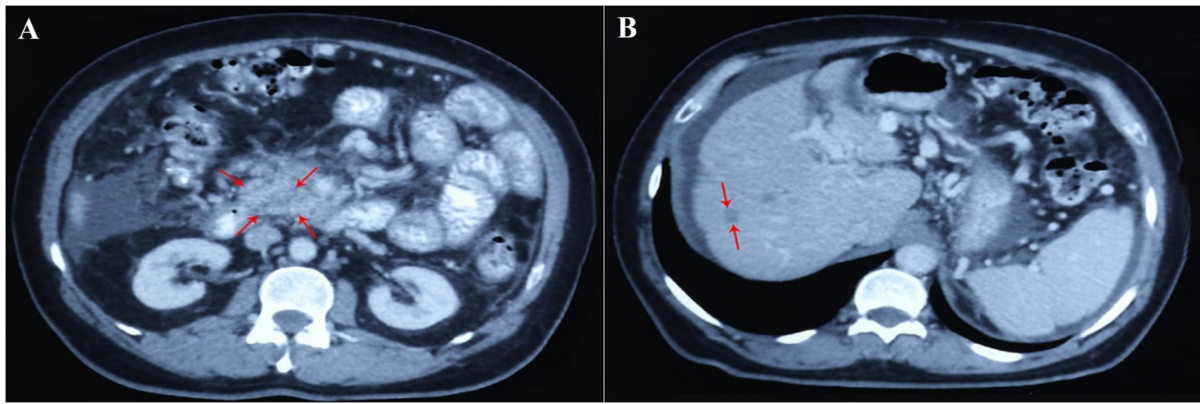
Post-selpercatinib treatment contrast-enhanced computed tomography abdomen axial section (venous phase) showing (A) reduction in the size of the pancreatic primary mass lesion (red arrows) to 3.3 (anteroposterior dimension) x 3.8 (transverse dimension) x 3.0 cm (craniocaudal dimension) along with (B) significant reduction in the number and size of hepatic metastases (red arrows), the largest measuring ~1.3x0.8 cm.
